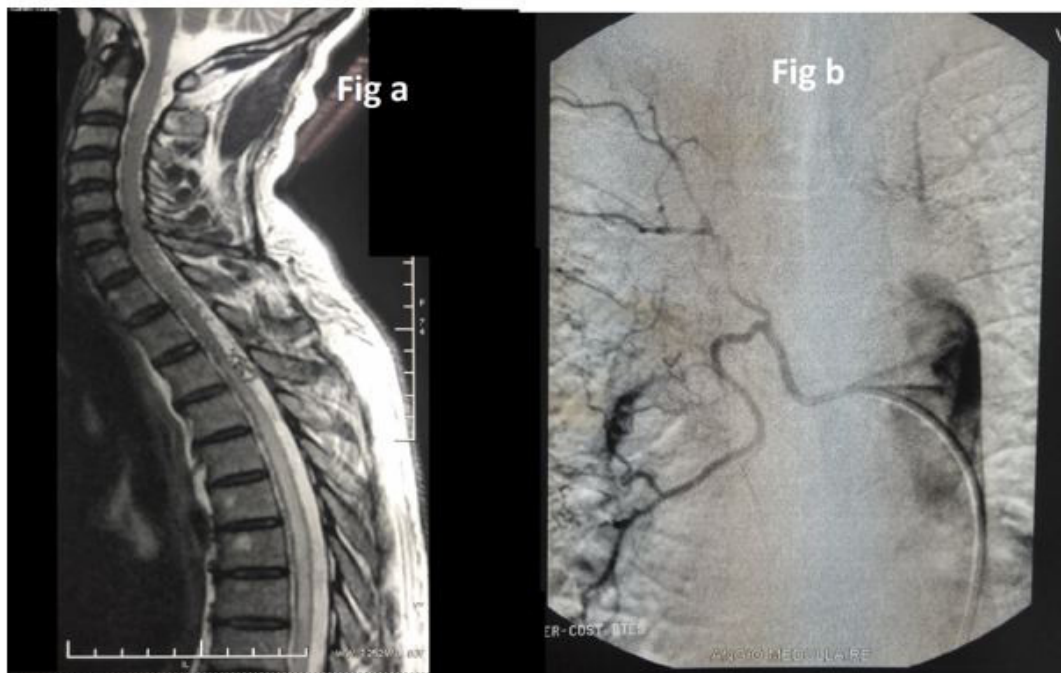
(a) Spinal MRI showed a serpiginous appearance of the spinal vessels with spinal edema which are in favor of SAVF. He had also a posterior intraspinal T2 hypersignal extended from D3 to L1, a sign of spinal cord ischemia. (b) Angiography confirmed the presence of epidural C6 to D3 AVF supplied by the right 4th intercostal artery
